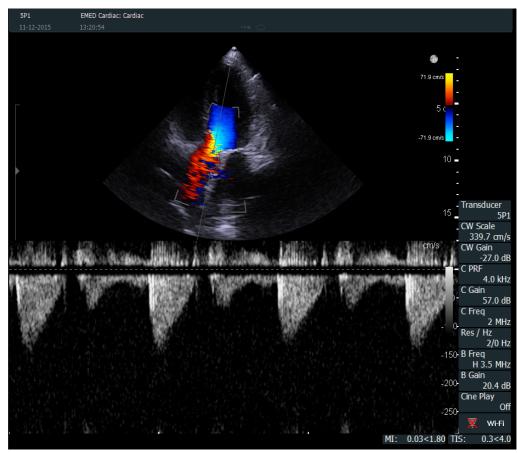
The CW Doppler line superimposed on a B-mode image.
